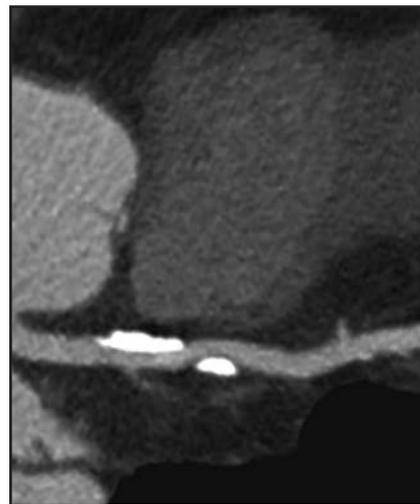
When motion is suppressed through very high temporal resolution, even severely calcified coronary arteries are often evaluable by CT angiography. This image, which was acquired on a dual-source CT, with a temporal resolution of 83 msec, clearly shows the lumen of the left anterior descending coronary artery, despite heavy calcification.
